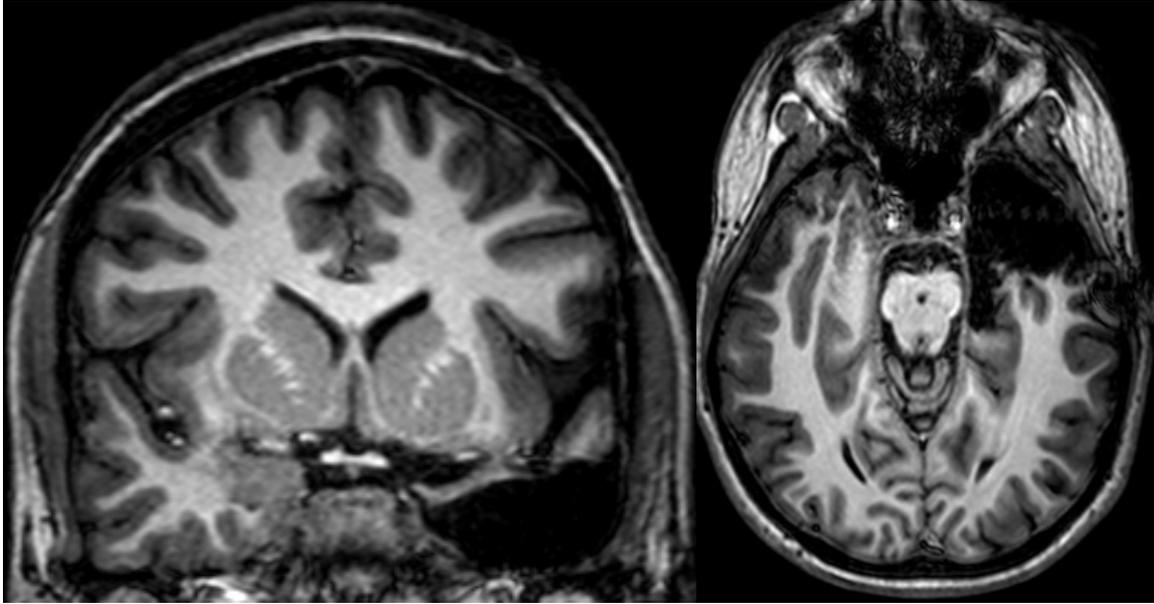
Post-operative MRI of temporal lobe resection (TLR).*
